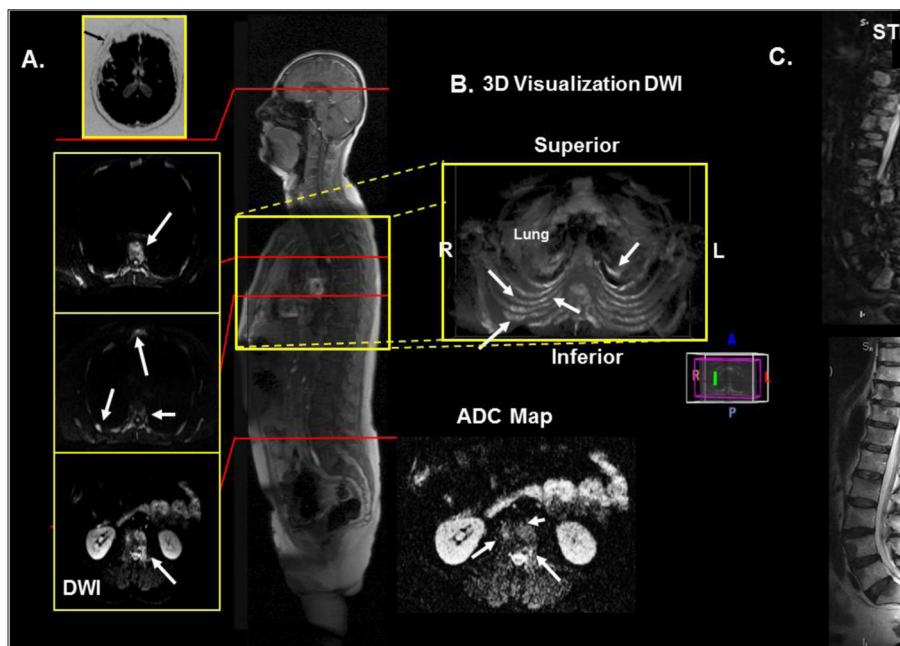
Demonstration of WB-MRI on a 66-year-old man with metastatic prostate cancer. A. Axial diffusion imaging through the thorax and pelvis shows multiple metastatic lesions in the ribs, sternum, and vertebrae. B. 3D visualization of the thorax showing the metastatic lesions in the chest. C. T2 and STIR imaging of the spine to correlate the metastatic lesions with the WB-MRI.
